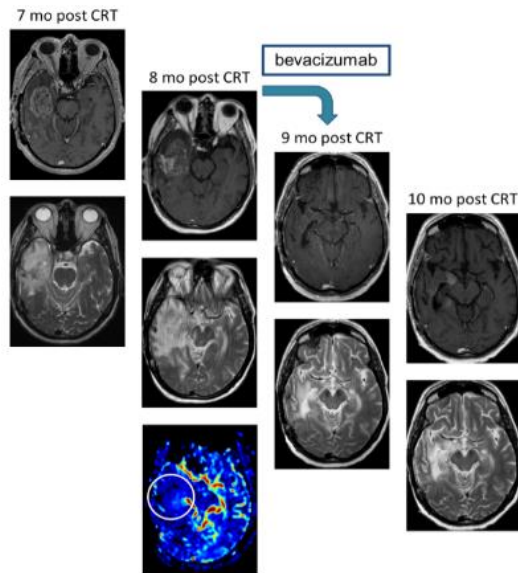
This Patient received Celldex vaccine (an investigational immunotherapy that targets the tumor specific oncogene EGFRv3) at 5 and 6 months after CRT and 4 monthly cycles of adjunct Temozolamide. A Dramatic increased mass effect was noted 7-8 months post CRT and 1-2 months post Celldex vaccine. T1+Gd MRI Column 1: 7 months after CRT showing residual enhancing lesion in the right temporal lobe. Column 2: 8 months after CRT showing increase size of the lesion and exuberant vasogenic edema and mass effect on the lateral ventricle and midline shift. DSC perfusion MRI 8 months after CRT showing decreased CBV in the enhancing area in the right temporal lobe, suggesting pseudoprogression. At this point Patient might be falsely classified as disease progression by updated RANO criteria. Patient was continued on Temozolamide based on our blood volume measurements. He was given one dose of Avastin as an anti-edema measure in addition to high dose of steroids. He had to be eventually taken off the clinical because the trial excluded patients on Avastin. Column 3: 9 months after CRT and 4 weeks after one dose of bevacizumab MRI showed significant improvement in the enhancement, vasogenic edema and mass effect. Column 4: 10 months after CRT and 8 weeks after bevacizumab showing minimal increase of enhancement and mass effect, still significantly better than before bevacizumab. This case clearly demonstrates the inadequacies of conventional MRI scans and RANO criteria and shows blood volume measurements is better imaging biomarker than enhancement.
